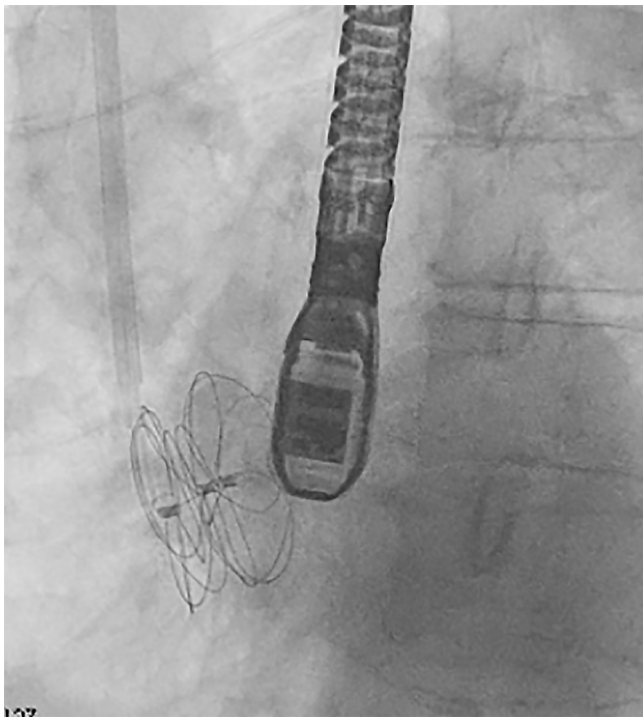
Radiographic image of Cardioform with transesophageal probe.
